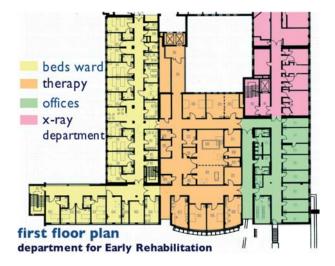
The authors' specially designed department for ENNR at Clemenshospital. L-shaped ground plan of the ENNR department as part of the neurosurgical clinic where all rooms are located on the first floor (1200 sqm) and connected by short access. Offices to the north, next to the X-ray department, and bed-rooms (single and twin beds, cardiology intensive care style) to the south-east. All necessary therapeutic and diagnostic facilities in the middle next to patients' rooms and two elevators and two staircases
